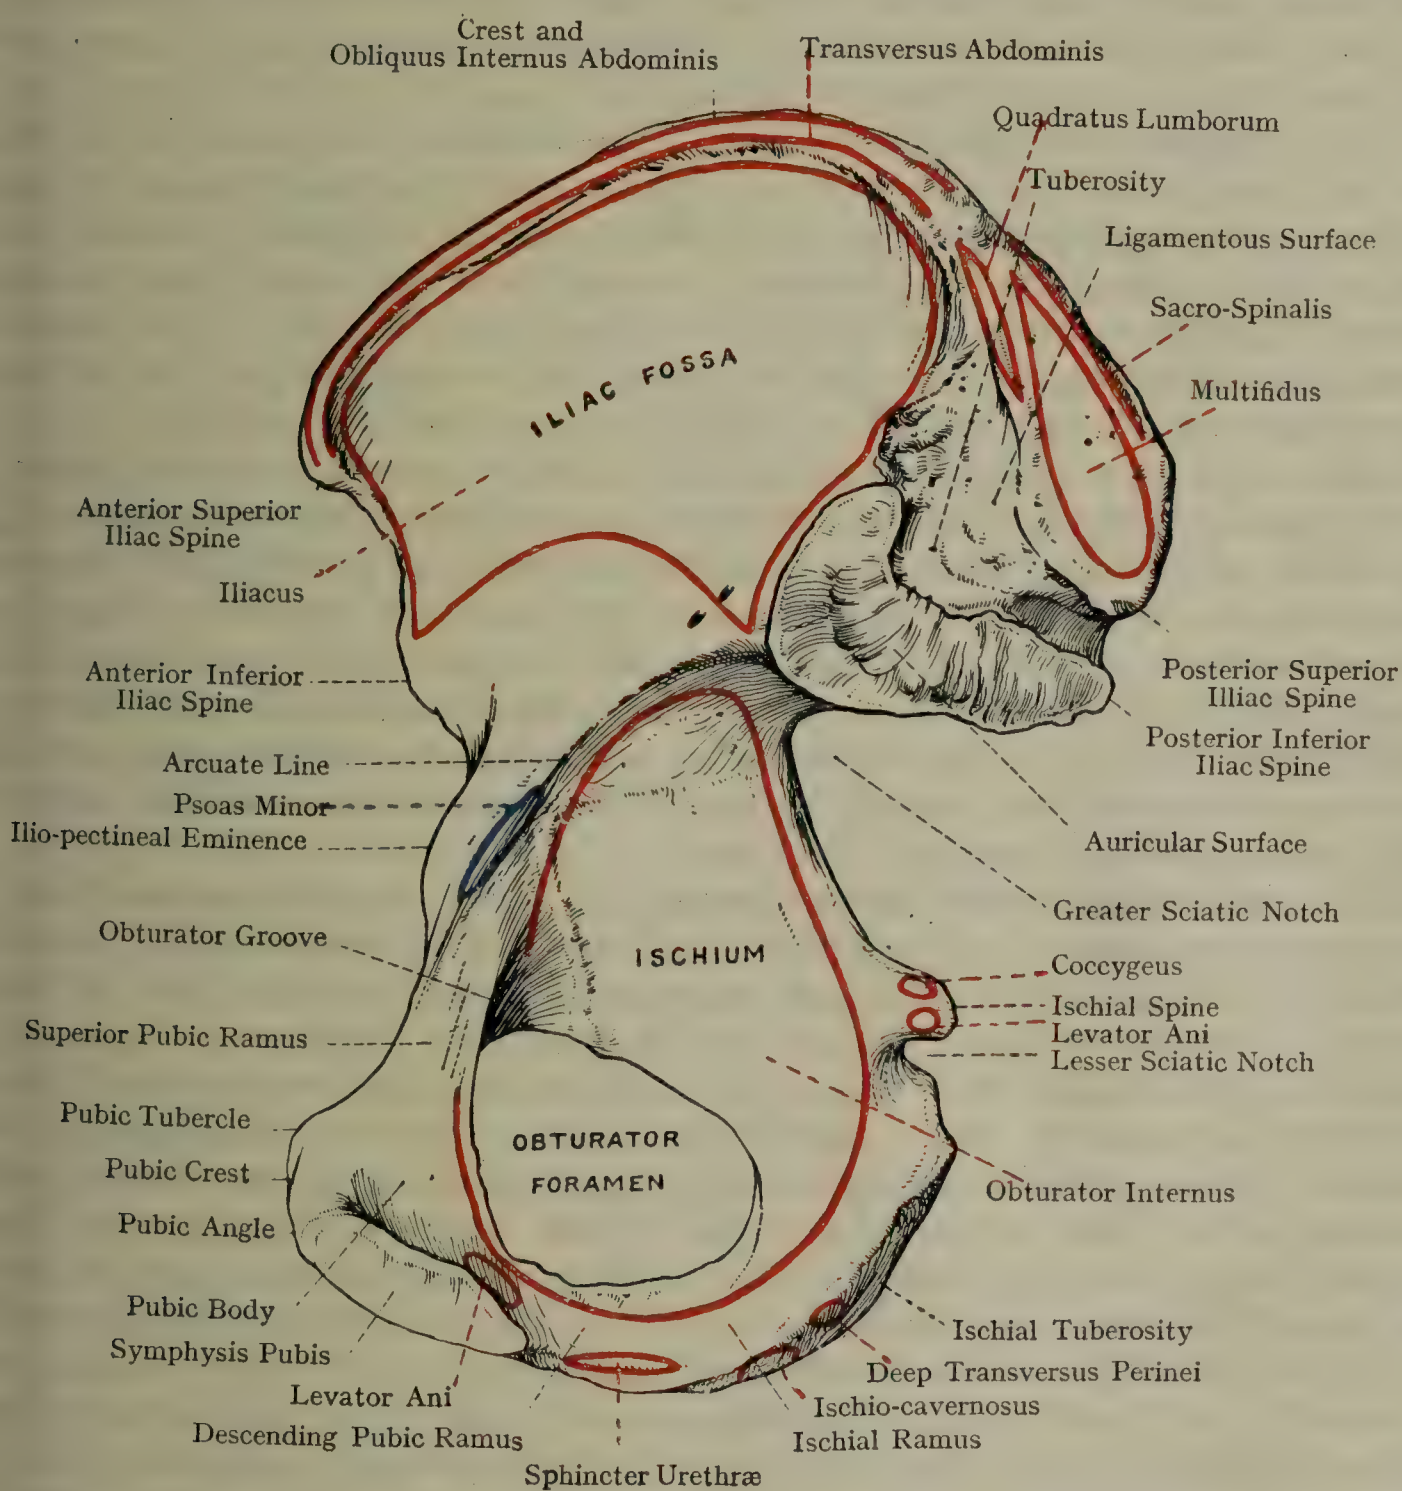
THE RIGHT HIP BONE (MEDIAL ASPECT).
